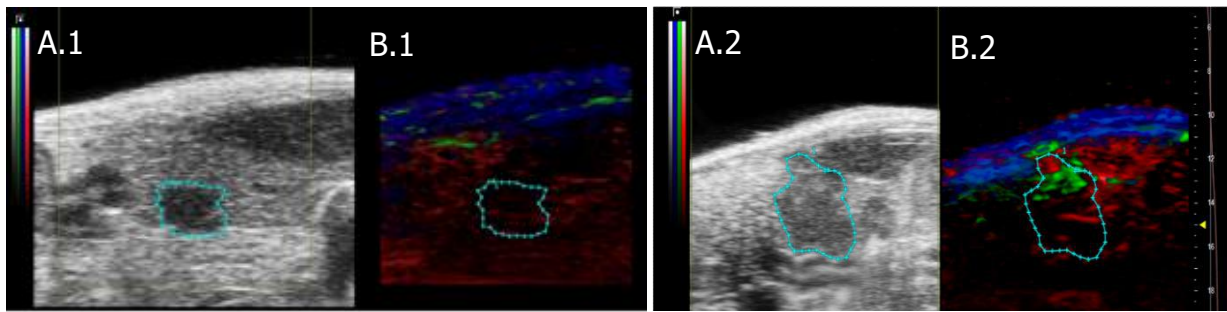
Two-dimensional ultrasound (A) and photoacoustic (B) images of tumor masses acquired one hour after intravenous injection of 1mg/kg ICGgreen (.1) and 16mg/kg of scDb-hERG1/β1 (.2). The tumor is evidence by cyan region. On PA imaging (B), red areas indicate the presence of oxyhemoglobin, blue areas indicate the presence of deoxyhemoglobin, and green spots indicate the ICG signal.
